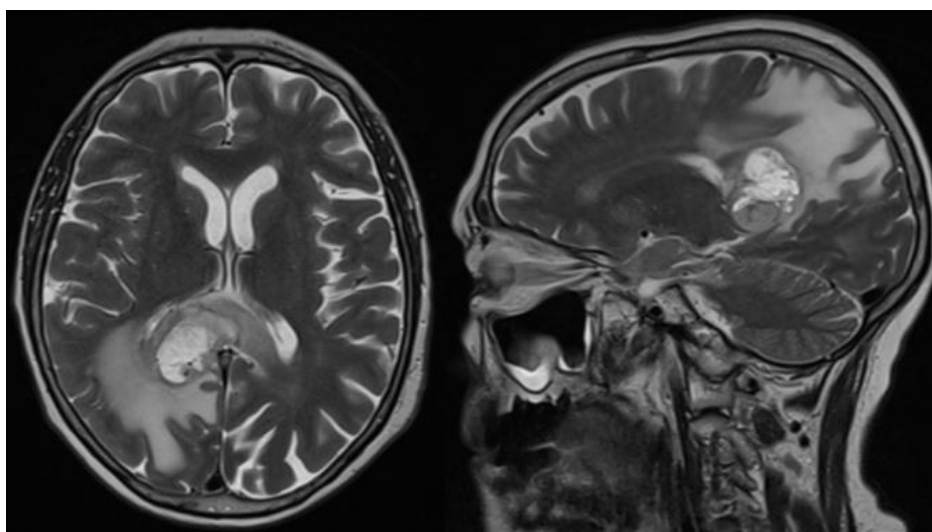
T2-weighted MRI GBM.
